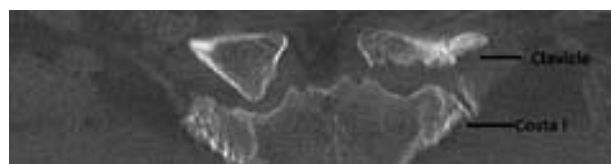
Postoperative coronal CT image showing an adequate costoclavicular space.
